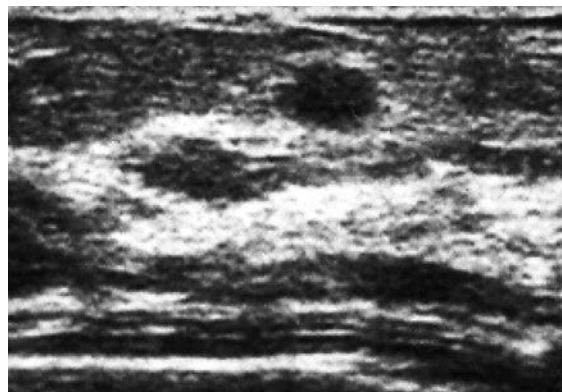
Breast ultrasound shows oval clearly demarcated hypoechoic node with slightly acoustic enhancement
